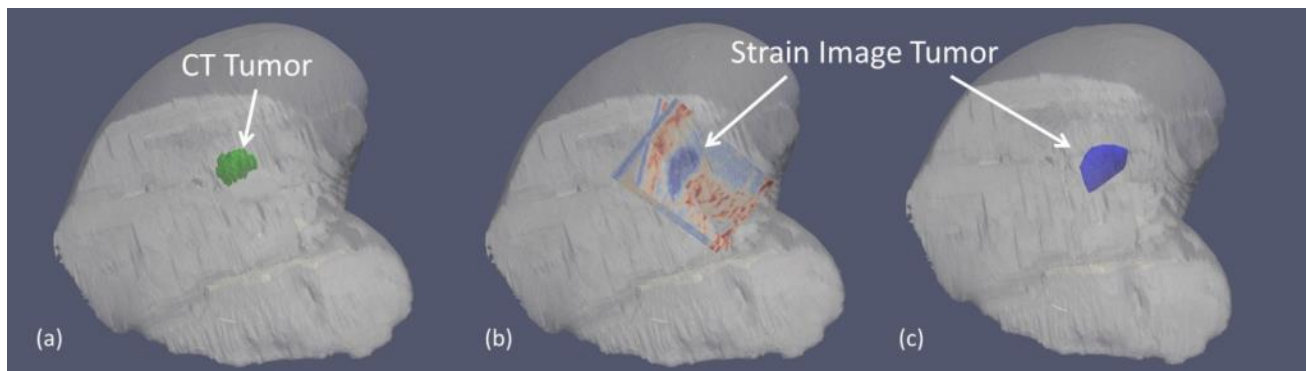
Embedded tumor surface generated from CT (a) and corresponding lesion shown in two roughly cross-sectional tracked strain images (b) and as a volume reconstructed from strain contours (c).
